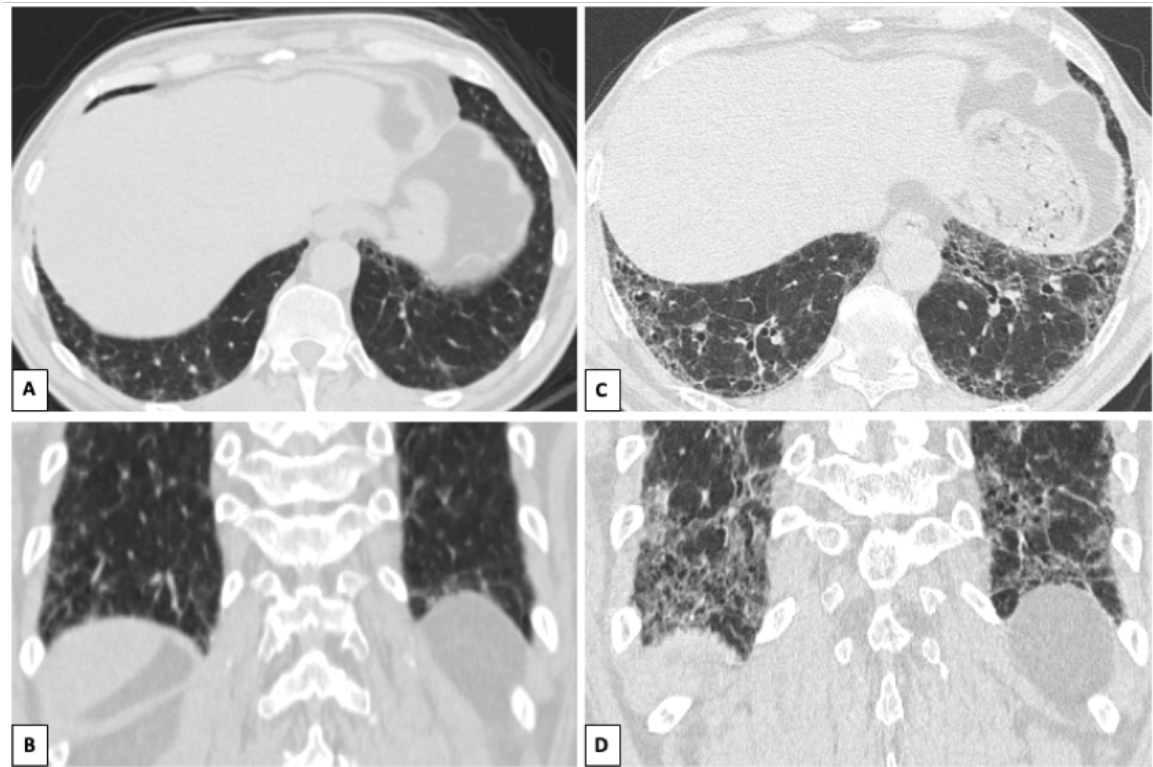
Severe progression of minimal reticular opacities detected on abdominal CT in 2009 (A and B) toward overt fibrosis in four years (C and D).
